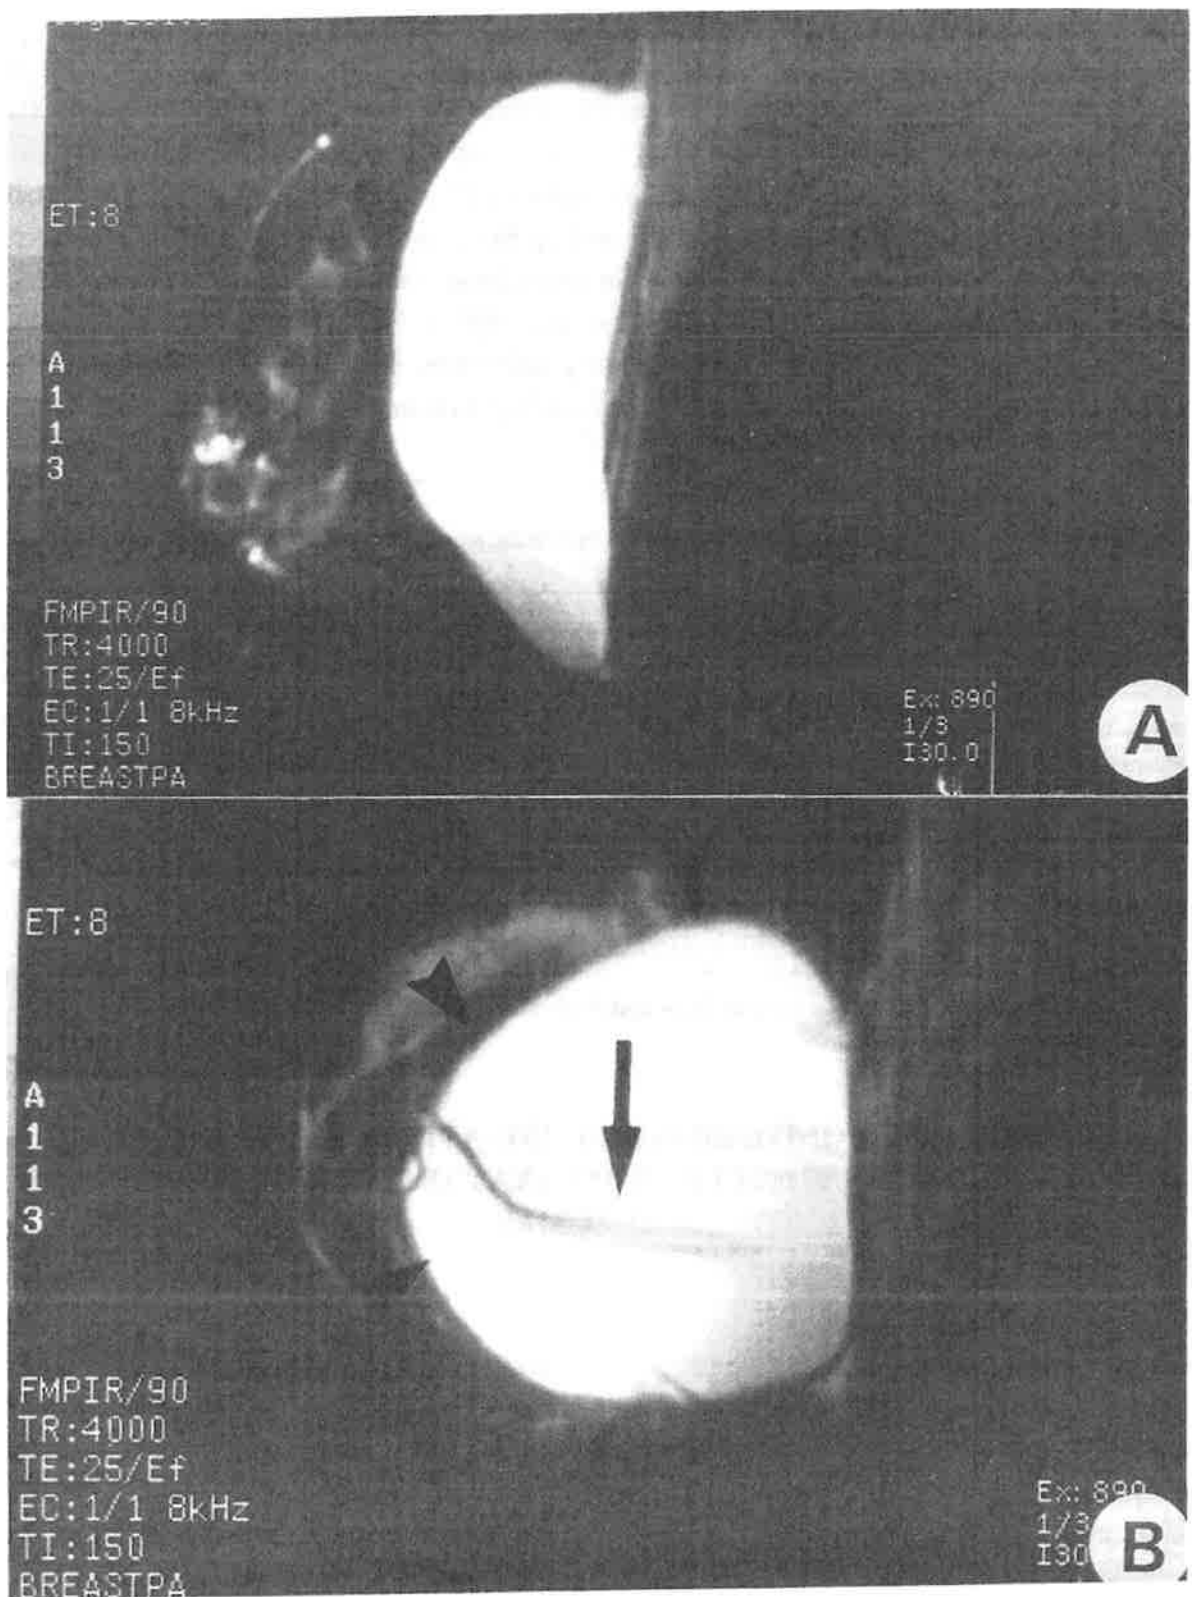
MRI breast examination of a middle-aged patient. A. T_1 -weighted MR image of a normal oval-shaped saline-filled silicone prosthesis implanted six months earlier in the right breast, acquired with an inversion-recovery sequence (FMPIR) (sagittal view, TR = 4000 msec, TE = 25 msec, TI = 150 msec). B. T_1 -weighted MR image of the implant in the left breast of the same patient. This image demonstrates a rounded prosthesis suggesting capsular contraction (arrowheads), and the structure within the prosthesis (arrow) appears to be a portion of the prosthesis envelope, suggesting intracapsular fold of the prosthesis (FMPIR sequence, sagittal view, TR = 400 msec, TE = 25 msec, TI = 150 msec).
